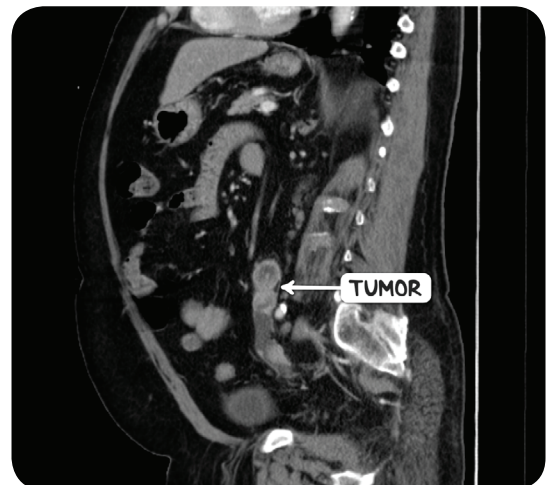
Transitional cell carcinoma can occur anywhere from the renal pelvis to the distal urethra. This coronal CT scan demonstrated a transitional cell carcinoma of the mid ureter.
